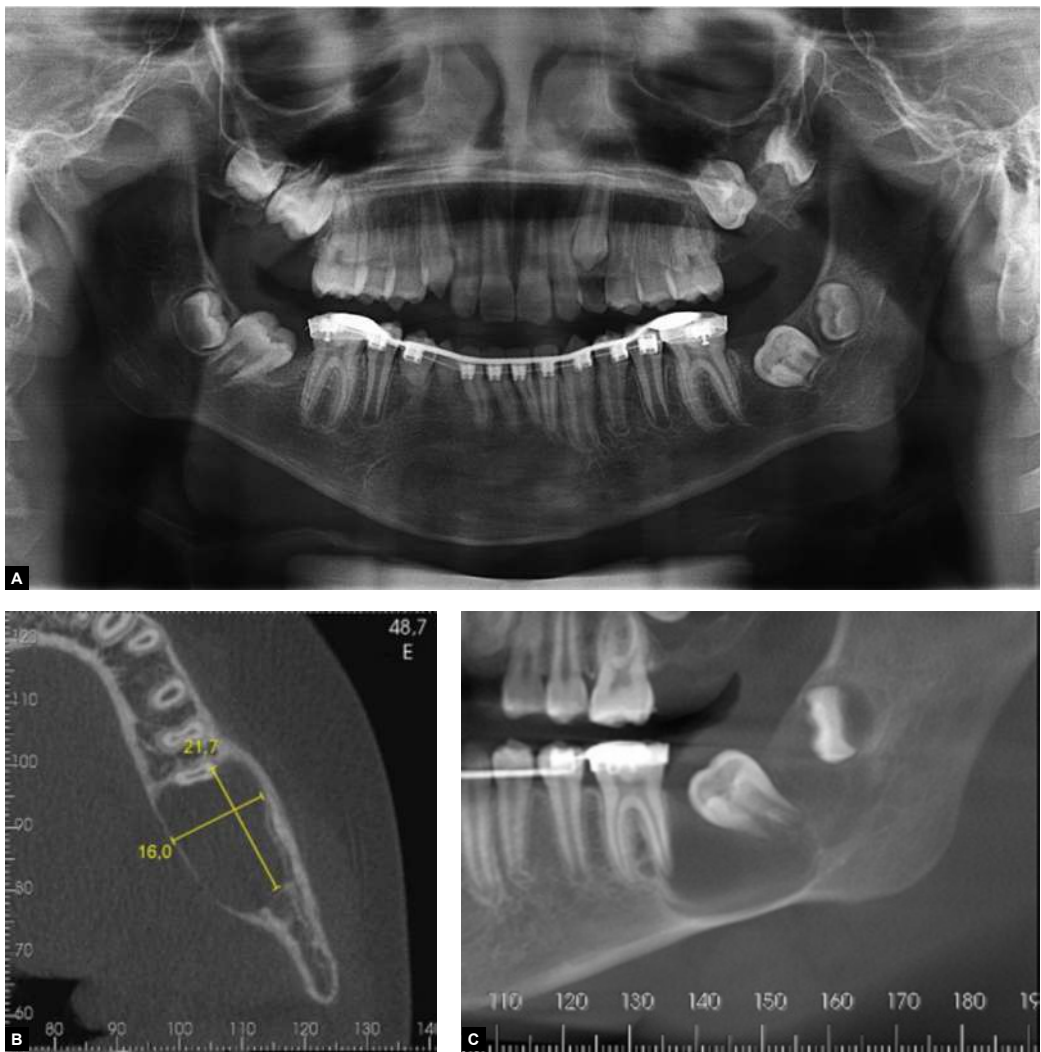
A) Radiographic image showing new radiolucent, well defined, multilocular area, involving the crowns of teeth #37 and #38, diagnosed as keratocyst. B, C) Hypodense area in body and left ramus of the mandible.
